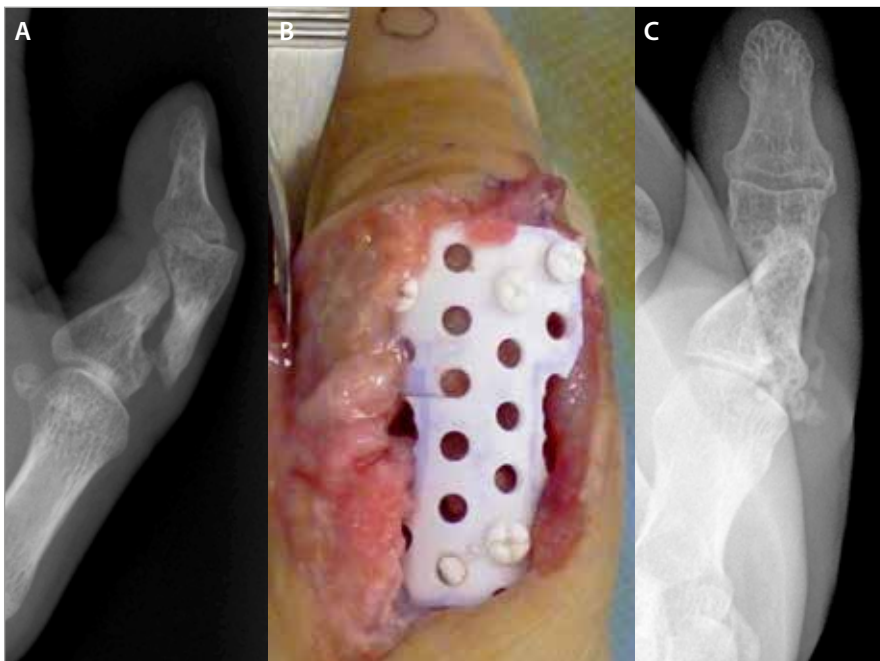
Radiographic and macroscopic evaluation (case 1). A) Preoperative X-ray (posterior-anterior view); B) operative finding; C) postoperative X-ray (posterior-anterior view) 6 months after mesh plate fixation.
